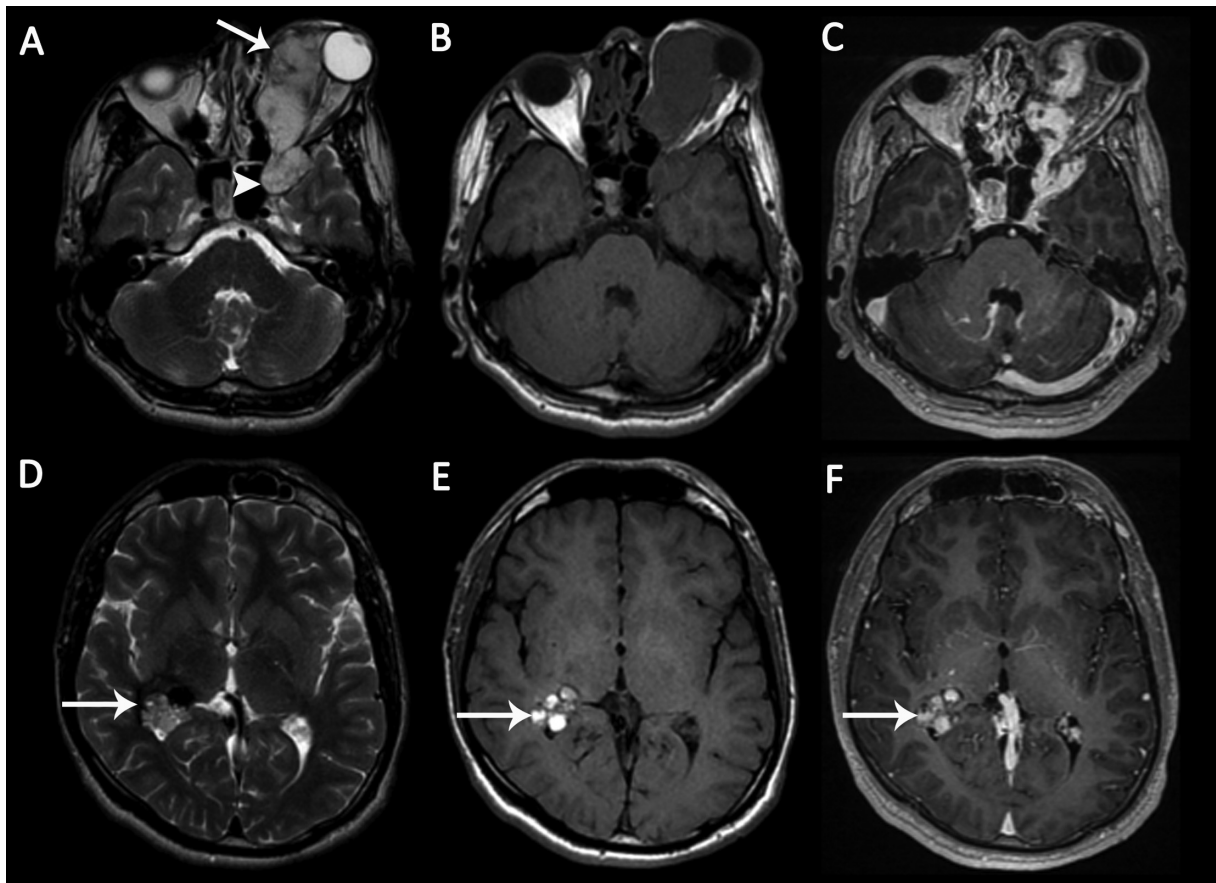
Large cavernous malformation in a 20-year-old male patient with painless proptosis of the left eye. (A) Axial T2-weighted image (T2WI) demonstrates a left orbital lobulated heterogeneous hyperintense lesion (arrow), extending to the anterior part of the left cavernous sinus (arrowhead). (B) The mass is hypointense on axial T1-weighted image (T1WI). (C) The mass shows early nonhomogeneous intense enhancement. Axial (D) T2WI and (E) axial T1WI demonstrate an incidental intraventricular cavernoma with cystic components in the right trigon (arrows). There are hemorrhagic signals within the lesion. (F) There is no enhancement on axial contrast-enhanced T1WI (arrow).
